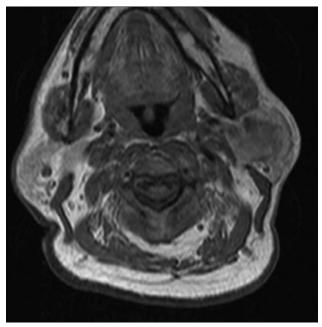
MRI axial plane image of the parotis mass axial before contrast injection.
